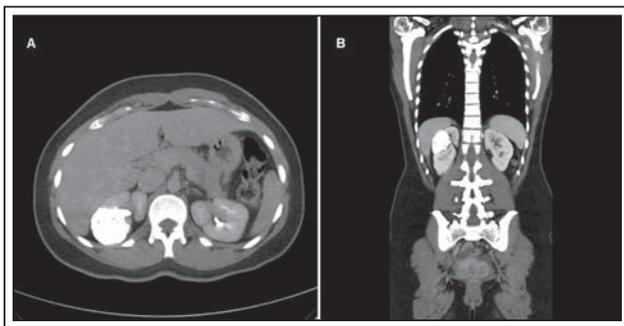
Axial (A) and coronal (B) reconstruction of abdominal CT scan revealing 4.8 cm calcified right renal mass.
